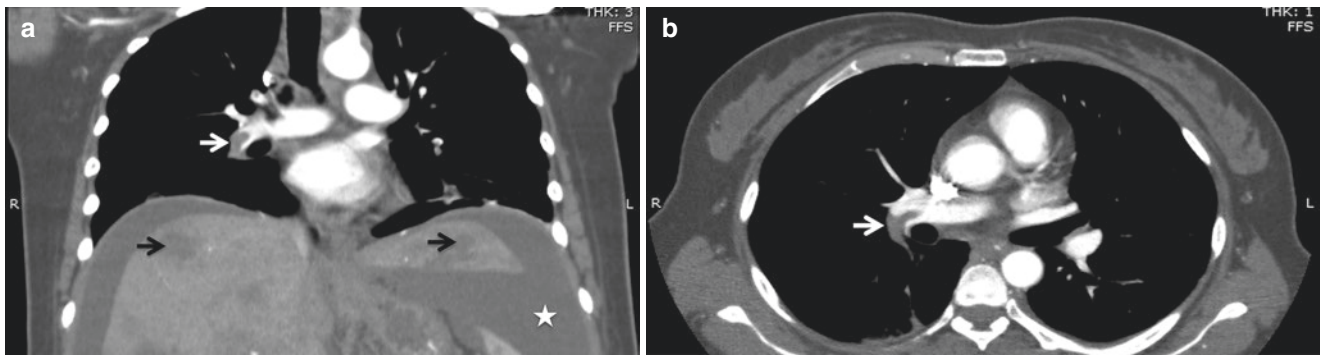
Coronal (a) and axial (b) contrast-enhanced chest CT images demonstrate a hypodense filling defect in the contrast-opacified lumen of the right main pulmonary artery, with extension into the interlobar
